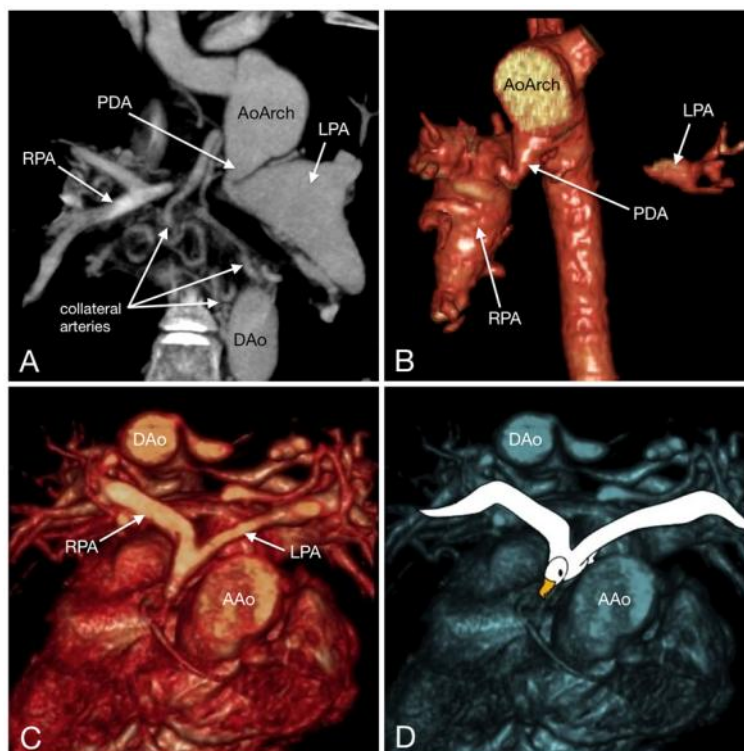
Pulmonary atresia with non-confluent (A and B) and confluent pulmonary arteries (C and D). MIP coronal image in A shows a PDA arising from a left-sided aorta supplying the dilated left pulmonary artery, a small right pulmonary artery, and multiple collateral arteries supplying the right lung. Volume rendered CT image in B shows a PDA arising from a right-sided aorta supplying the dilated right pulmonary artery and a diminutive floating left pulmonary artery. Volume rendered CT images in C and D showing small but confluent pulmonary arteries (‘‘seagull sign’’ in D) in a 3-year-old patient with pulmonary atresia. RPA = right pulmonary artery, LPA = left pulmonary artery, PDA = patent ductus arteriosus, AAo = ascending aorta, AoArch = aortic arch, DAo = descending aorta.
